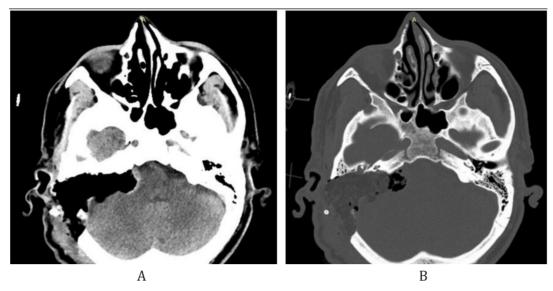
Postoperative computed tomography images show: A – postoperative defect; B – obliteration of the defect with fat tissue.
